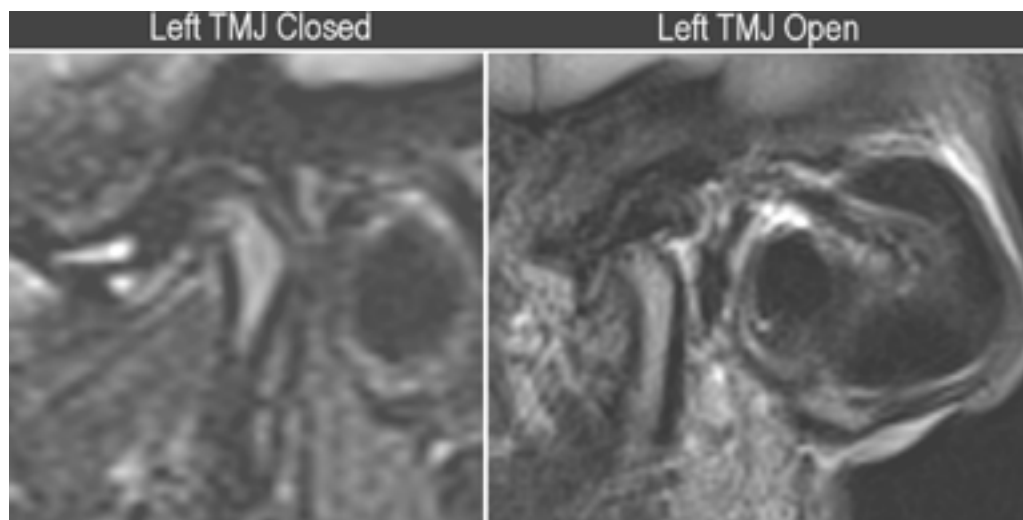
MRI of Left TMJ in closed position and open position. The disk appears to be missing in the closed position in this sagittal view and unfortunately not coronal view was taken. A lesser internal derangement is the partial disk displacement with reduction (PDDR, Piper 3a). In this case the disk slips off of the lateral pole during closure and the reduces during opening. This produces a single vibration of the ipsilateral side with about 50 % transfer to the contralateral side because the disk moves antero-medially when it displaces, posterolaterally when it reduces. This PDDR can be easily missed in MRIs, depending on how thoroughly the images are reviewed. It is very convenient and cost effective to have the JVA right in the practice for a quick indication of TM joint function.
